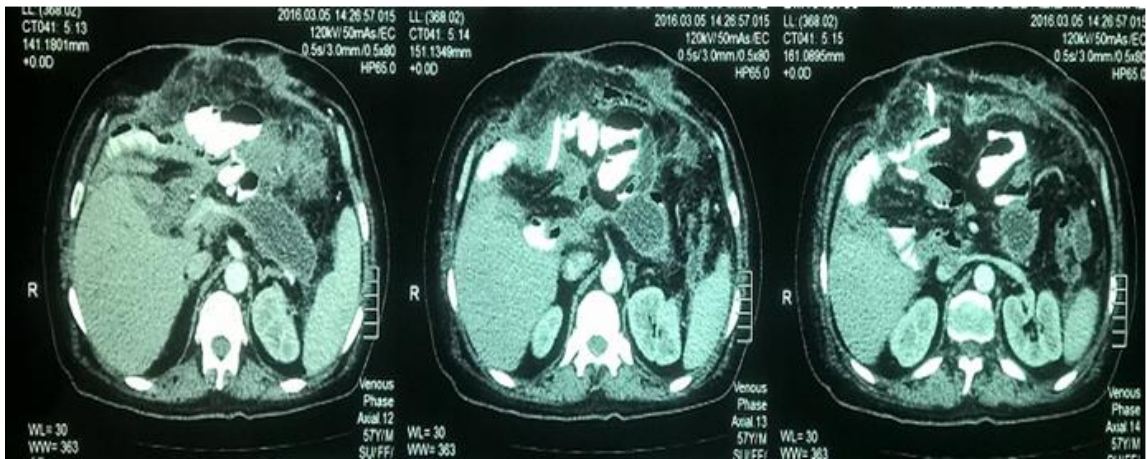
CT post total pancreatectomy complicated by multi-septated collection.
